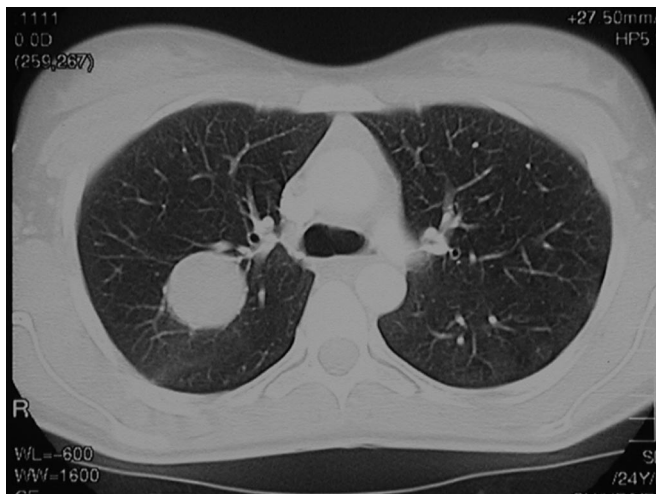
Baseline CT scan of the chest.
